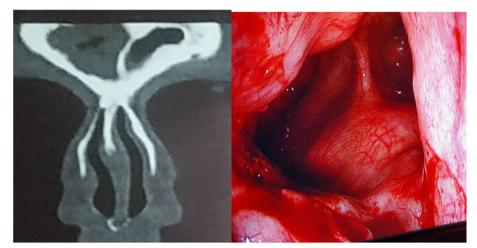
Preoperative CT scan and intraoperative endoscopic picture of right frontal sinus. Left showing pre-operative CT scan with right frontal sinus opacity, on right side showing intraoperative endoscopic picture of the same patient after 3 weeks. Frontal sinus is clear and there was no pathology seen intraoperatively
